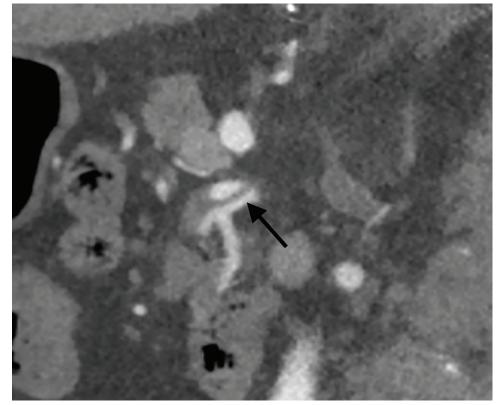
Computed tomography angiogram during acute presentation demonstrates dissection of superior mesenteric artery with flow in the true lumen inferiorly (*arrow*) filling the inferior pancreaticoduodenal artery. Some flow is evident superiorly in the false lumen above the dissection flap, with thrombosis distally.
